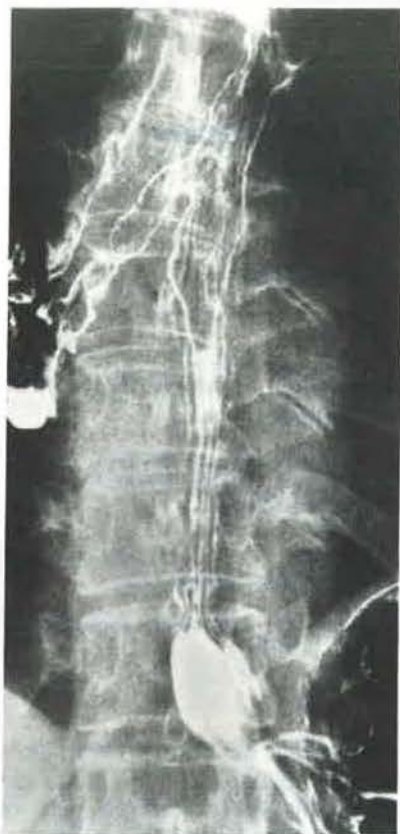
Radiograph of oesophagus.
